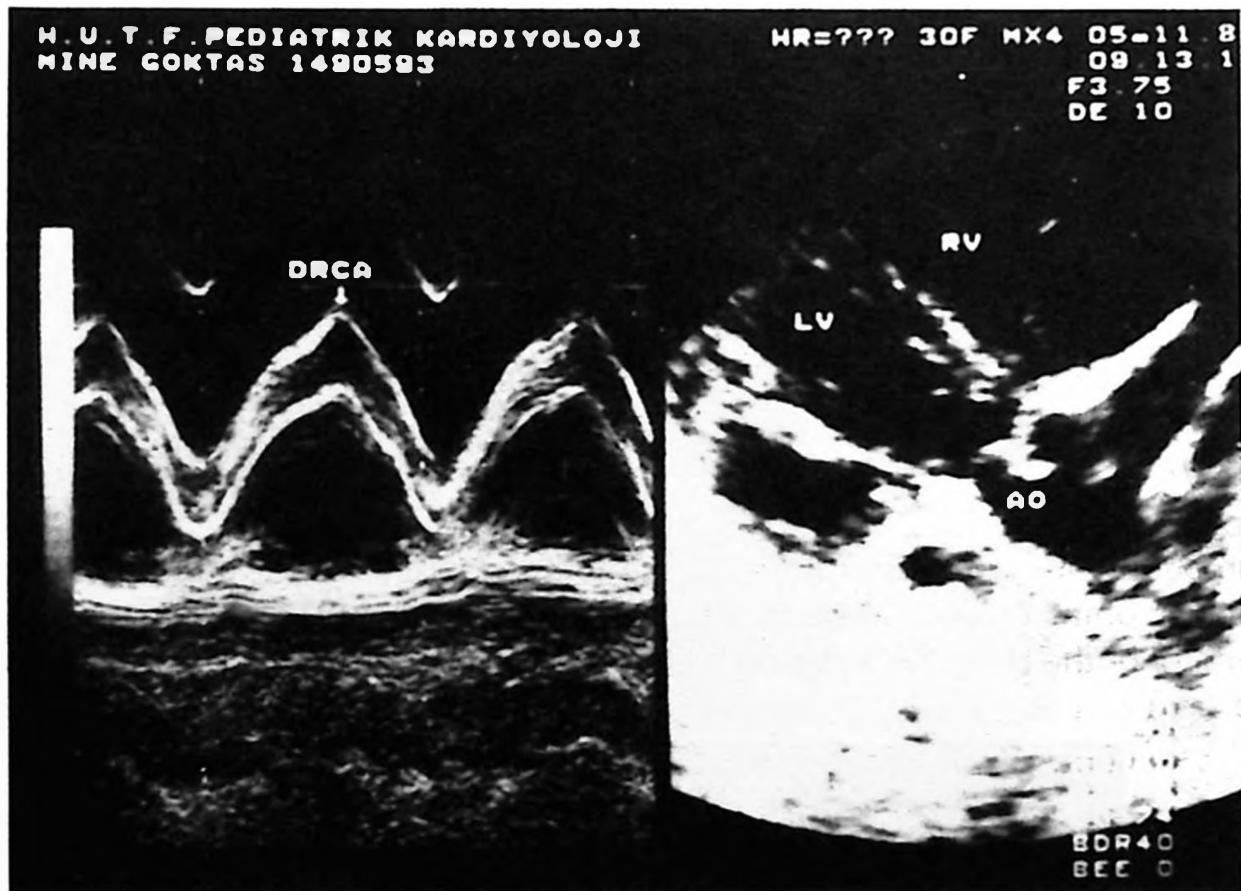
Dilated right coronary artery (arrow) is demonstrated by two-dimensional (right) and M-mode echocardiography (left).
